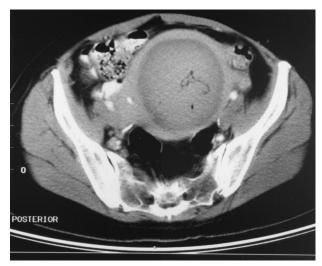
MRI taken one day after uterine fibroid embolization. Artifactual air bubbles are noted inside of myoma.
